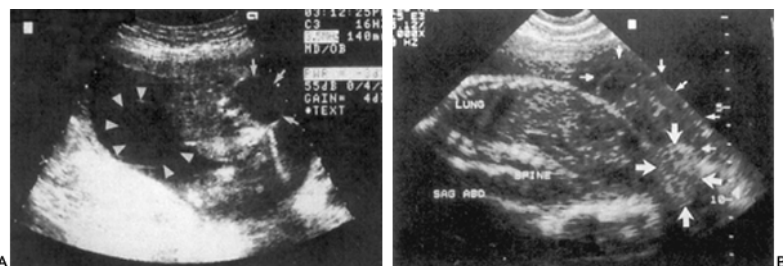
35. Antenatal ultrasonogram of fetus with cloacal exstrophy. A: At 22 weeks of gestation, this transverse image reveals a cloacal membrane anteriorly (*arrowheads*) and lumbar myelomeningocele posteriorly (*arrows*). B: At 30 weeks of gestation, an omphalocele may be seen (*small arrows*) along with an exstrophic bladder and bowel inferiorly (*large arrows*). (Reprinted from Austin P, Homsey YL, Gearhart JP, et al. The prenatal diagnosis of cloacal exstrophy. *J Urol* 1998;160:1180, with permission.)
